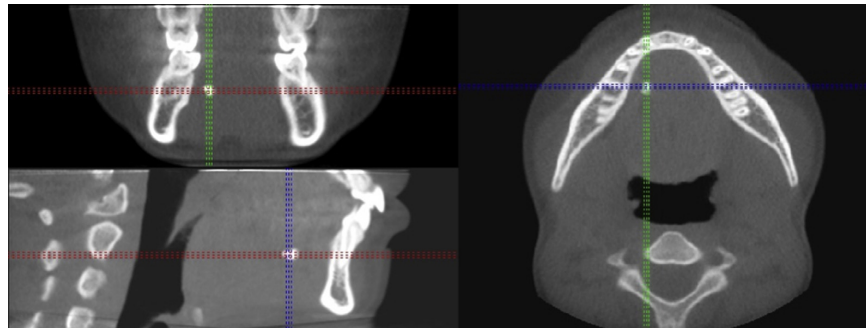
Cone-beam computed tomography images (coronal, sagittal, and axial) demonstrate right-sided sialolithiasis submandibularis. The sialolith is located in the Wharton duct.
